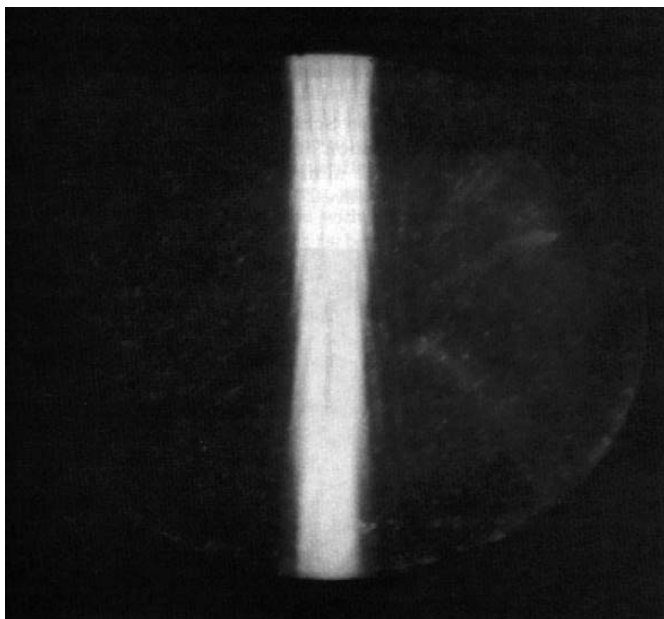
Schlieren image of an ultrasound beam.
